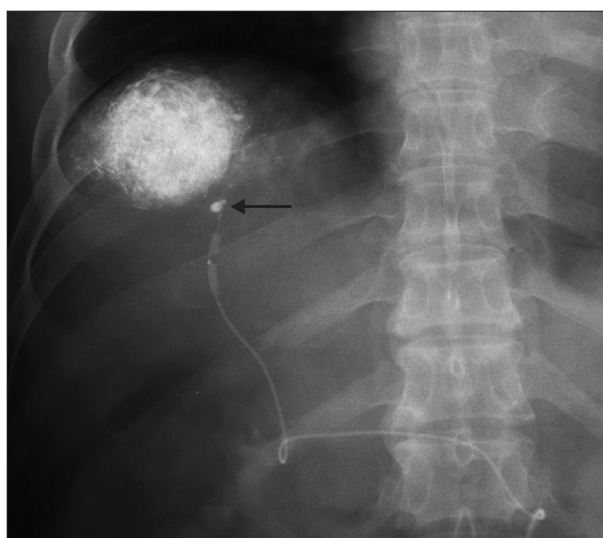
The first case of super-selective lipiodol balloon-occluded transarterial chemoembolization performed in 1991 using a coronary angioplasty balloon catheter. A coronary angioplasty catheter was passed through a 7 F guiding catheter and placed in subsegment 8 artery. Lipiodol emulsion was infused under balloon-occlusion and a spot radiography was obtained before embolization of gelatin fragments. Densely accumulated lipiodol in hepatocellular carcinoma nodule and adhesion of a lipiodol droplet at the catheter tip were seen (arrow).
